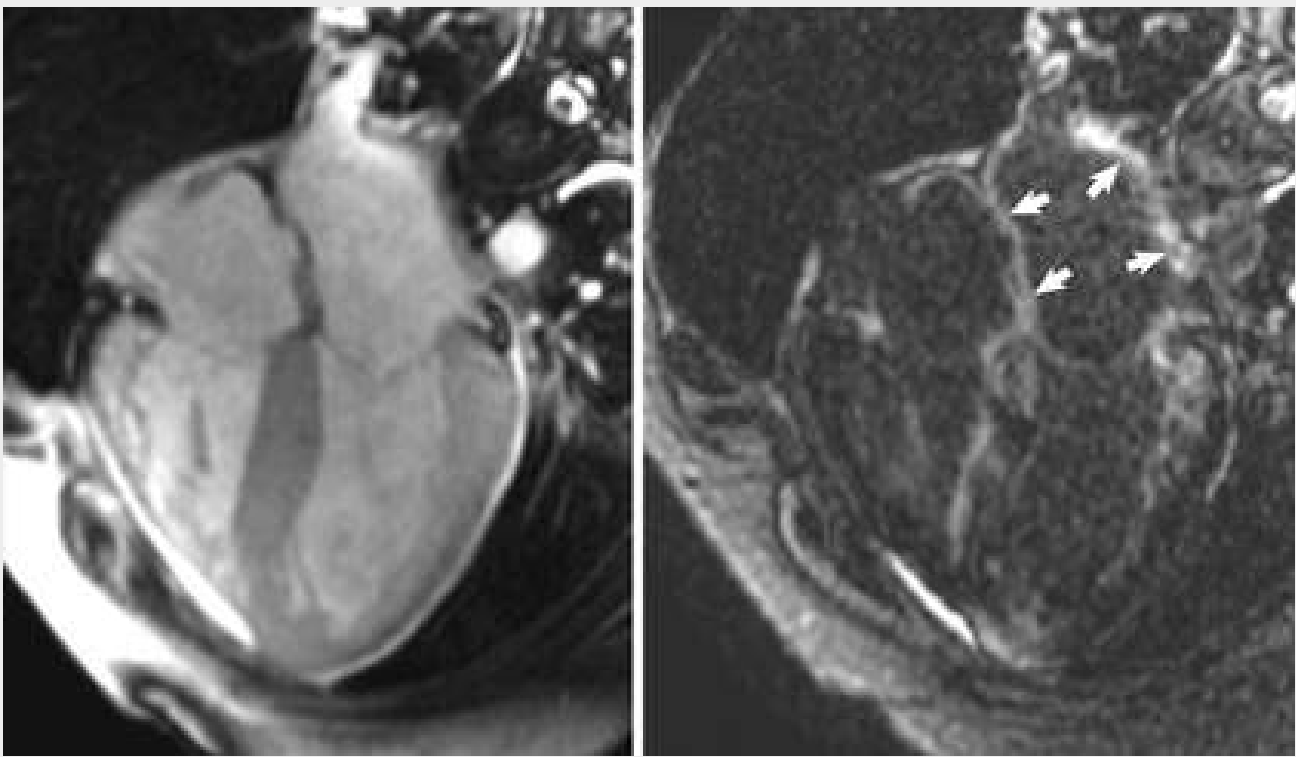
Cardiac MRI in a patient with amyloid cardiomyopathy. The left panel shows a thickened left ventricle with biatrial enlargement and a thickened atrial septum. The right panel is from the same patient and shows extensive delayed gadolinium enhancement involving not only the ventricles but also the atria extensively (*arrows*). Atrial amyloid deposition is associated with impaired atrial contraction and intraatrial thrombus formation.
